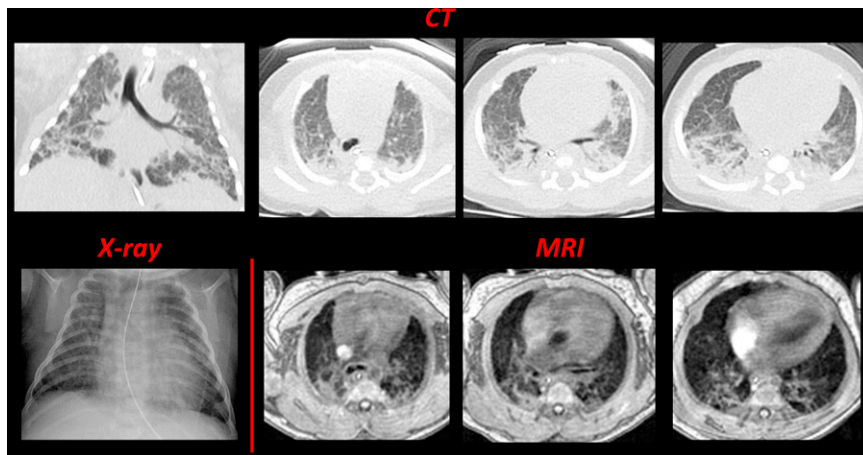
Comparing computed tomography (CT), radiograph, and magnetic resonance imaging (MRI) in a neonatal intensive care unit patient diagnosed with bronchopulmonary dysplasia (BPD) (BPD1, 23-wk gestational age at birth). The *top* contains four inspiratory CT images (clinically ordered; 80 kVp; 500 ms exposure), one representative coronal slice (*left*) and three axial slices, which were selected to best match the three fast gradient echo MRI images in the *bottom*. The chest radiograph (*bottom left*) is also included for comparison. CT and chest radiograph images were acquired at Day -1 and Day -4 , respectively, relative to MRI acquisition (Day 0). The radiologic scores (Table 2) were 12 and 9, respectively for the CT and MRIs.
